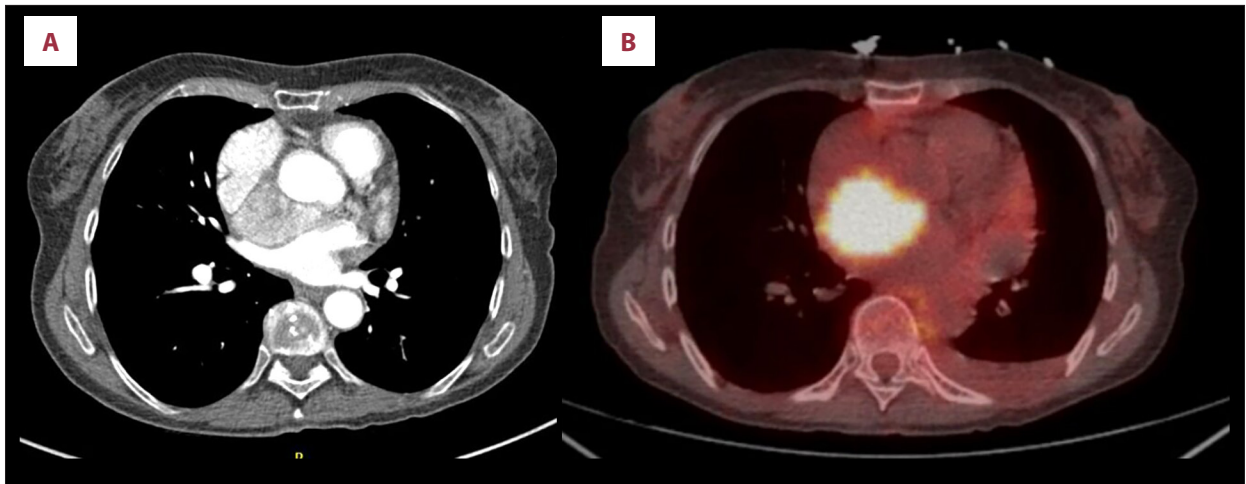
(A) Contrast-enhanced computed tomography of the chest revealing a well-defined hypervascular right retroatrial mediastinal mass. (B) Metaiodobenzylguanidine (MIBG) positron emission tomography showing intense tracer uptake within the mass.
